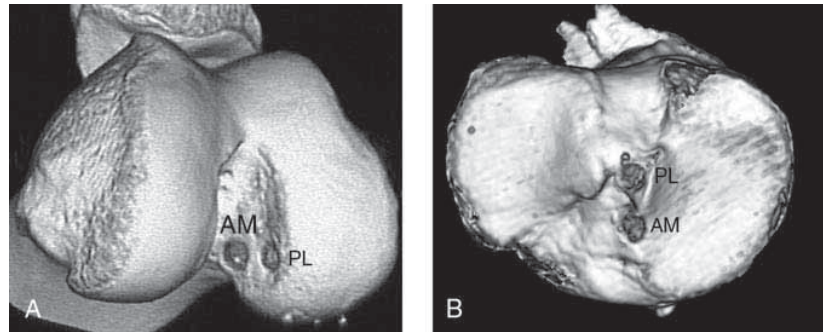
A, A three-dimensional CT scan of the AM and PL femoral tunnels. The average diameter of the AM tunnel is 7 mm, and the PL tunnel is 6 mm. The distance between the centers of the tunnels is 8 to 9 mm. Both femoral tunnels are located behind the resident's ridge (also called lateral intercondylar ridge) when the notch is viewed from the AM portal. B, CT scan showing the tibial tunnels; the PL tibial tunnel is posterior and slightly lateral to the AM tunnel.
